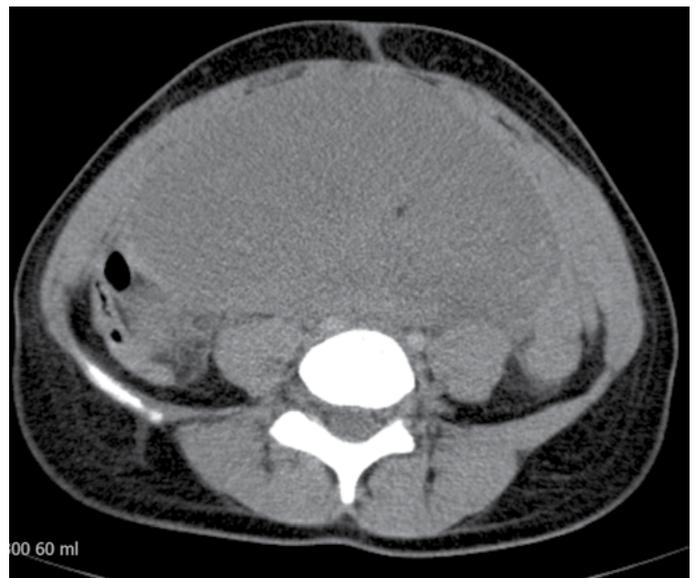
Computed tomography of the abdominal cavity and small pelvis. Cross section.
